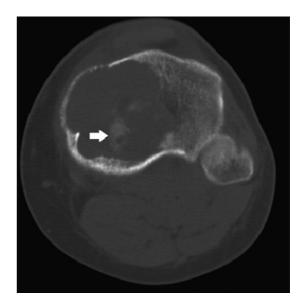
Axial computed tomography shows that the lesion is causing endosteal scalloping, with incipient disruption of the cortex, and is slightly expansile. In addition there is faint, amorphous calcification within the tumor (arrow). There is no associated soft tissue mass.
